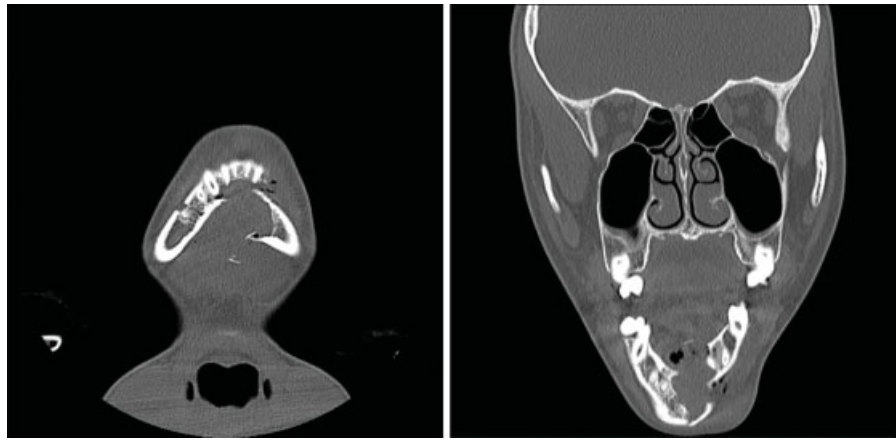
Coronal computed tomography (CT) scan revealing a parasymphyseal fracture in line with a cystic cavity.
